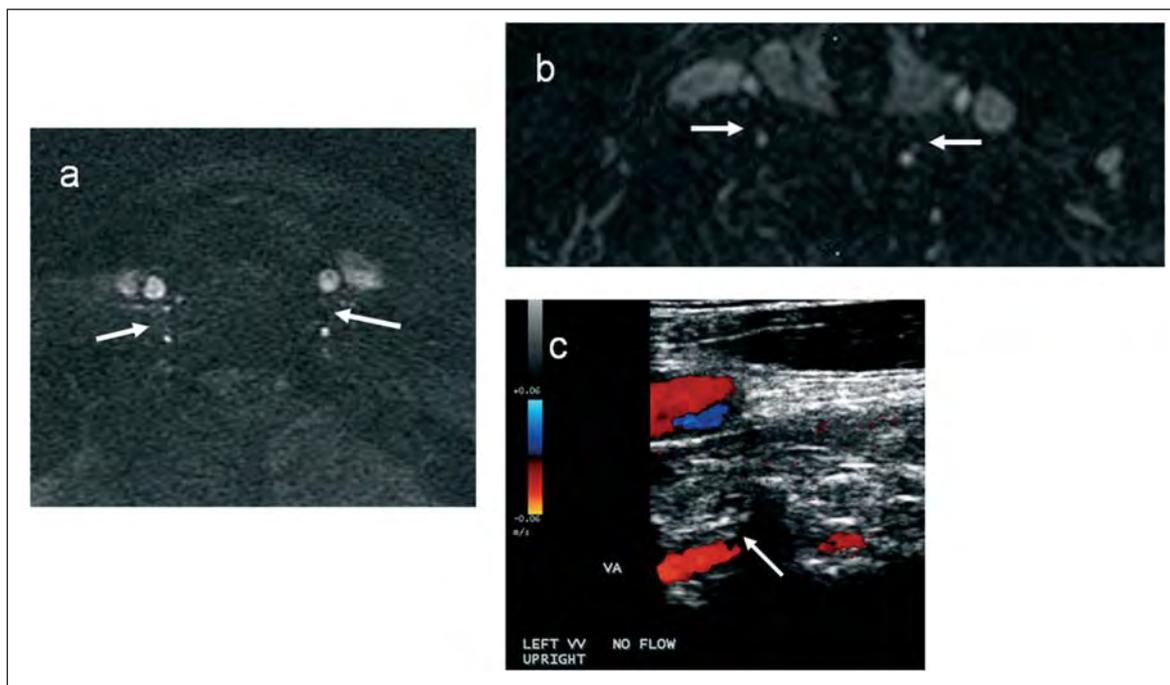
Examples of vertebral vein (VV) flow abnormalities on Doppler sonography and MR venography: (a) no visible flow on axial 2D time-of-flight and (b) enhanced axial 3D time resolved imaging of contrast kinetics in both VVs; (c) no visible flow in the left VV in upright position on Doppler sonography.
